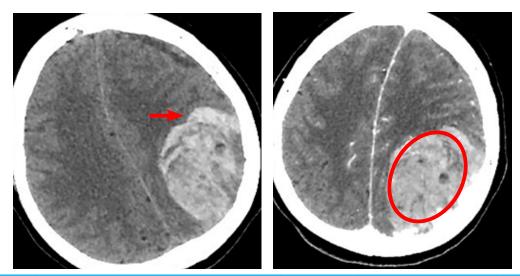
CT and CTA revealed a heterogeneous intraparenchymal hemorrhage in the left parietal lobe with midline shift (A) (marked by the arrow) and a peripheral contrast-enhancing mas. (marked by the circle) (B).
